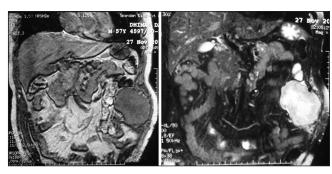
MRI-whole abdomen: Space occupying lesion in the left abdominal wall, iso-intense to muscles on TIWI, hyper-intense on T2W1
